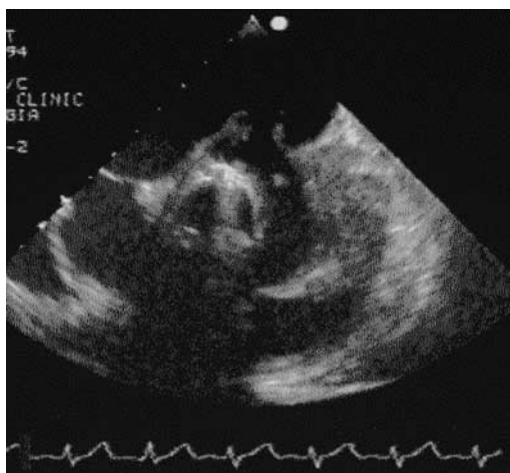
Transoesophageal echocardiographic image of a prosthetic aortic valve endocarditis. A peri-prosthetic abscess cavity is ruptured communicating the left sinus of Valsalva with the left atrium.
